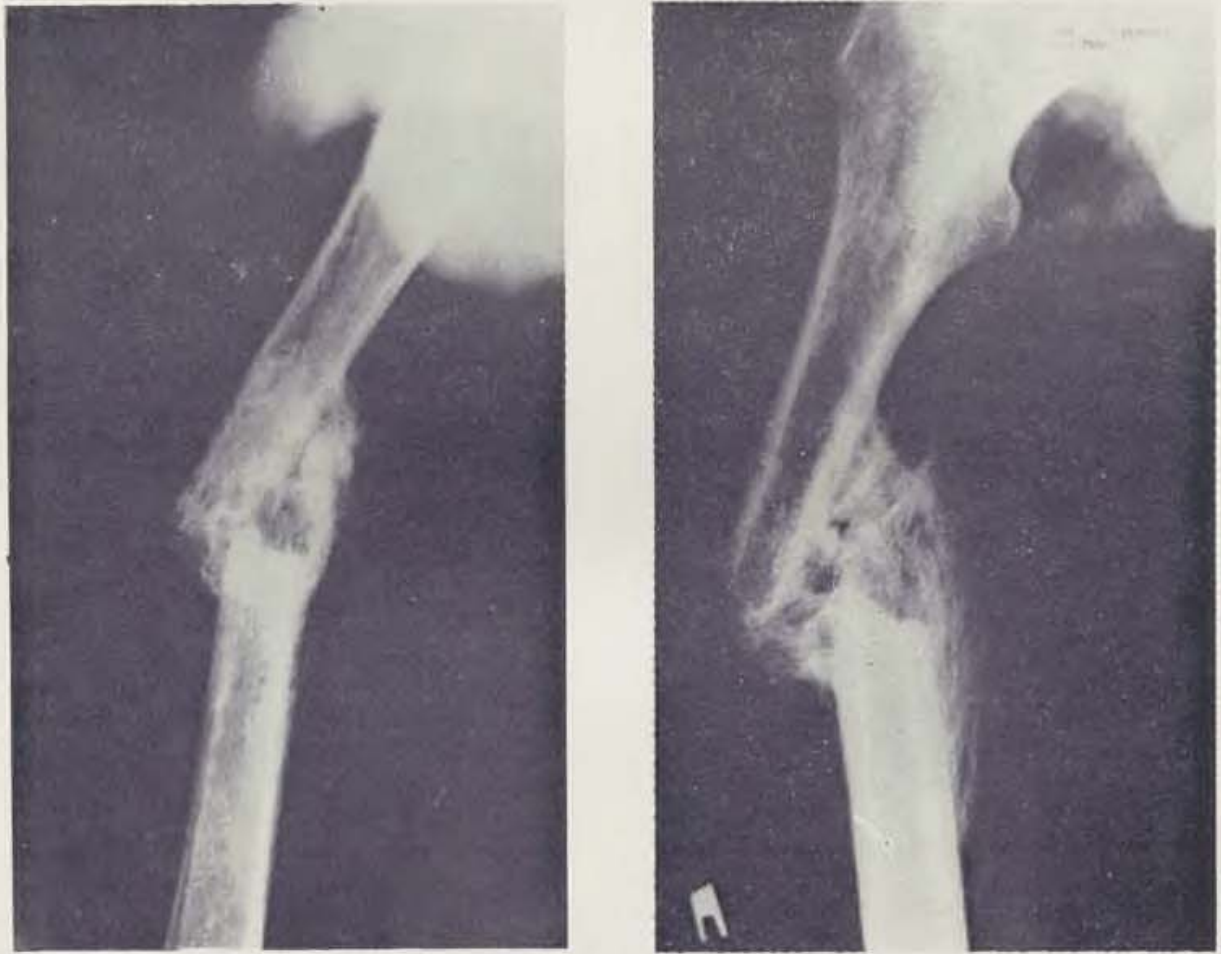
X-ray of united femur fracture 8½ months after injury in the same patient
